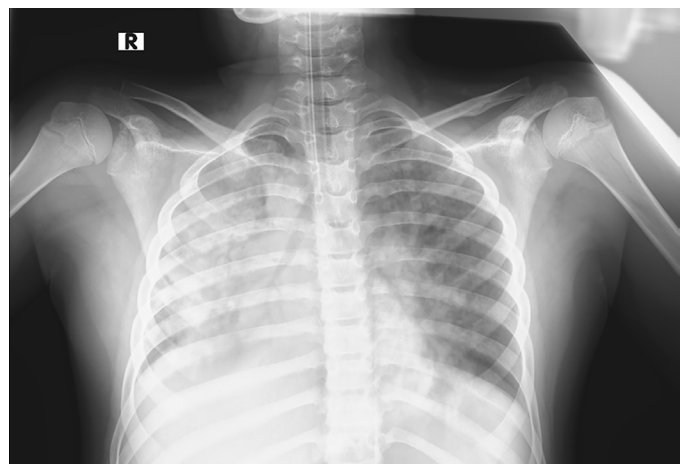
Bilateral perihilar infiltrations and bronchial airway filling on posterior-anterior chest radiograph images
